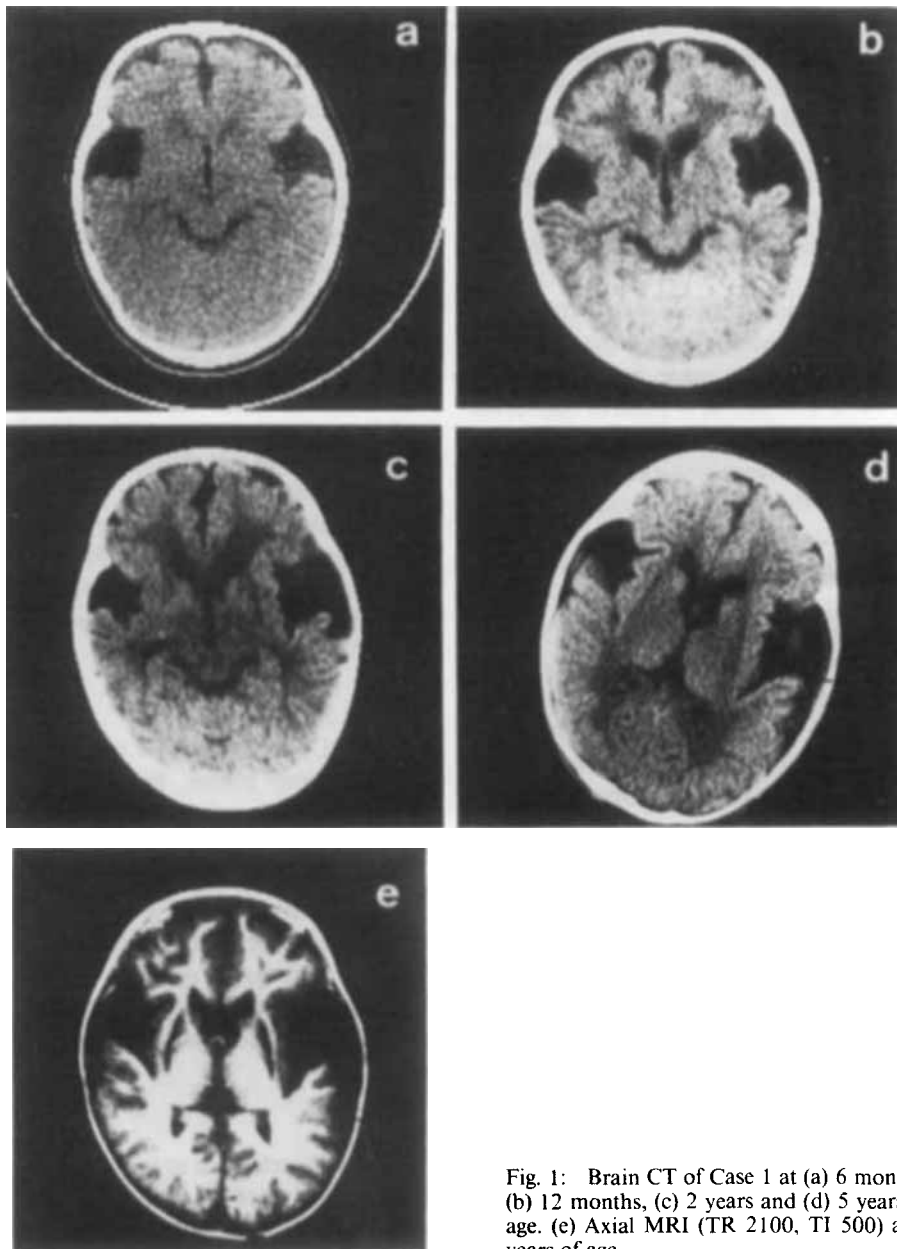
Brain CT of Case 1 at (a) 6 months, (b) 12 months, (c) 2 years and (d) 5 years of age. (e) Axial MRI (TR 2100, TI 500) at 4 years of age.
